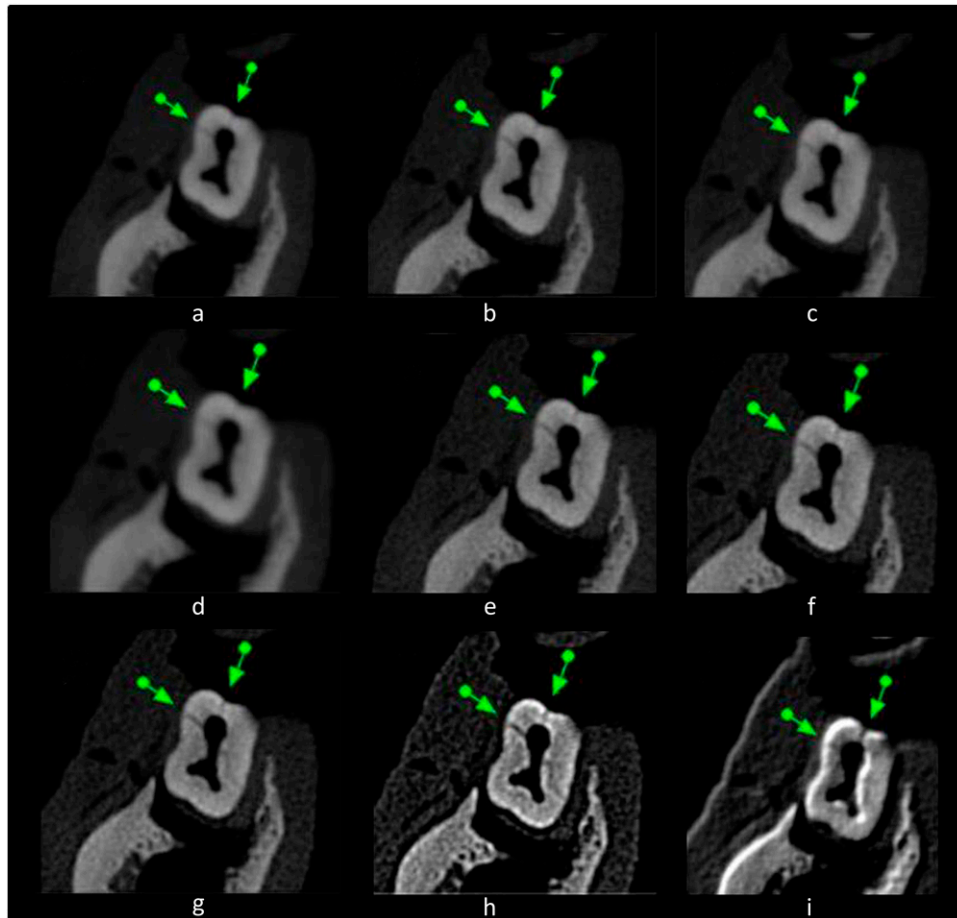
Axial cone beam CT slices show the longitudinal root fracture (indicated by arrows) in first mandibular molar with (a) no filter, (b) Sharpen Mild, (c) Sharpen Super Mild, (d) S9, (e) Sharpen, (f) Sharpen 3 × 3, (g) Angio Sharpen Medium 5 × 5, (h) Angio Sharpen High 5 × 5 and (i) Shadow 3 × 3.
